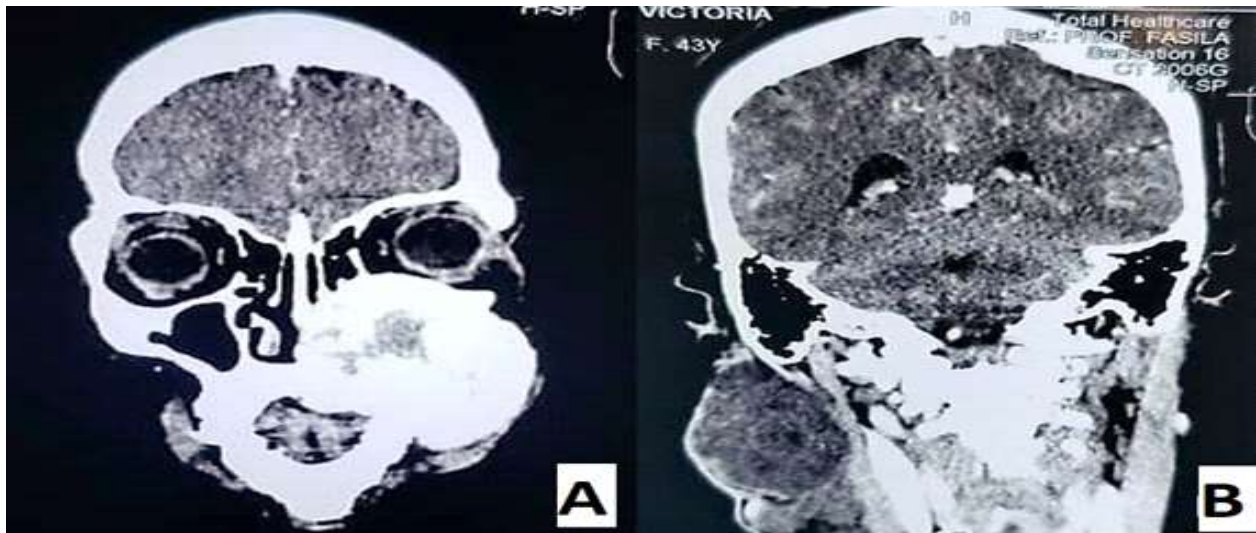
Craniofacial coronal computed tomography scan of the patient showing (A) a well circumscribed hyperdense mass with areas of hypodensity at the centre in the left maxillary region, (B) a circumscribed heterogeneously enhancing mixed density mass at the right lateral aspect of the jaw
